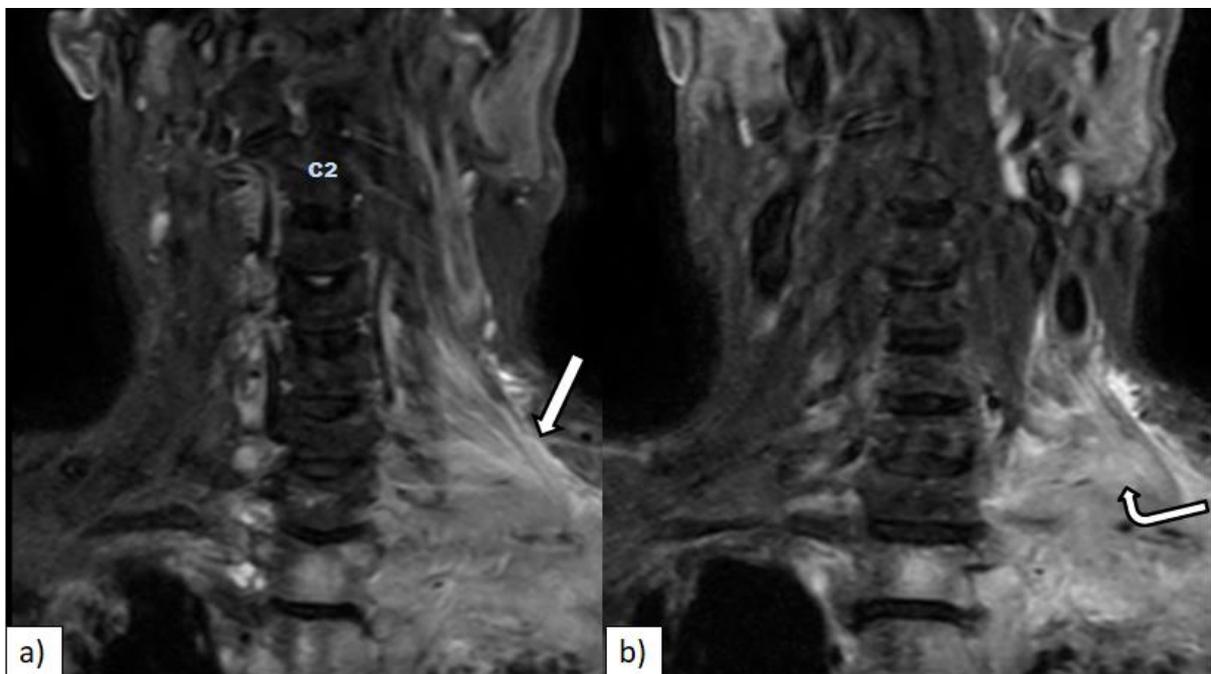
MRI STIR Coronal images of neck- a) shows the edematous & hyperintense nerve roots (straight arrow). b) Left apical hyperintense mass is seen extending superiorly with indistinct trunks & divisions of brachial plexus (curved arrow), suggestive of infiltration.
